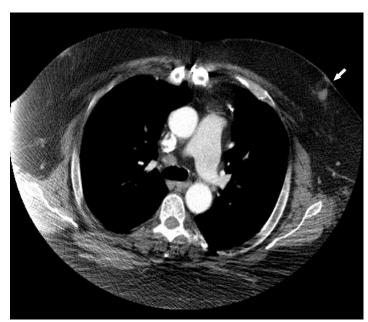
(left). 58-year-old man with benign simple breast cyst: Axial CT section through the chest after intravenous contrast, mediastinal window shows a 13×12 mm soft tissue mass (Houndsfield unit = 30) of indeterminate etiology in the left breast just posterior to the nipple. (GE Medical Systems LightSpeed 16, mAs=439, kVp=120, slice thickness=3.75mm, Intravenous contrast Omnipaque 350 was administered: 150 mLs, 2.5 ml/s, dose-length products =1217.03 mGy·cm.)
